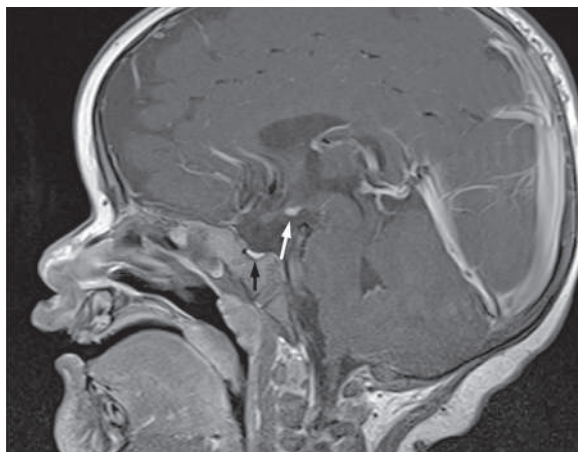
Sagittal T1 weighted MRI shows an ectopic posterior pituitary (white arrow) and a small anterior pituitary (black arrow). (From Giannopoulos EZ, Rohrer T, Hoffmann P, et al. Solitary median maxillary central incisor. *J Pediatr*. 2015;167:770, App Fig. 1.)
